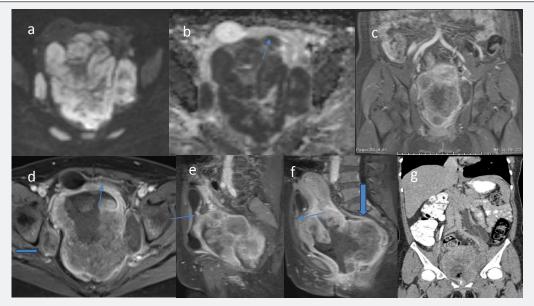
Large mass and enlarge lymph nodes showing remarkable diffusion restriction (image a) with dark signal in corresponding ADC (image b). T1 weighted sequence showing isointense heterogeneous mass (images not shown) Post-contrast exam reveals heterogeneous enhancement with irregular thick wall of urinary bladder showing enhancement (thin arrow in image d,e &f). UB catheter noted. Irregular wall also noted in ADC (Thin arrow in b) Re-demonstration of enlarged bilateral iliac lymph nodes showing heterogeneous similar post-contrast enhancement (Transverse arrow in image d). Focal adjacent rectal wall involvement again seen (vertical arrow in image f). CT done showing no liver metastasis. Again left hydro ureter seen (image g). Suggestion of posterior urethral wall involvement by large mass (star in image f).
